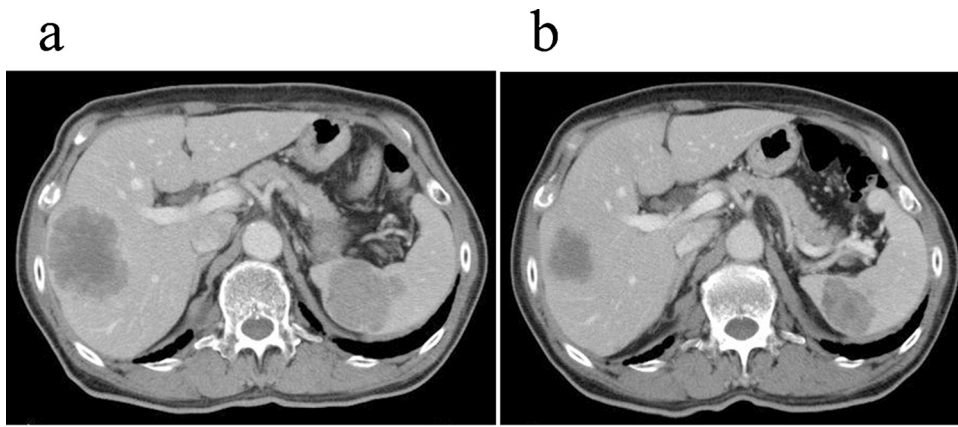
Abdominal computed tomography (CT) findings. (a) before rectal surgery (b) after chemotherapy. An abdominal CT scan performed after chemotherapy demonstrated significant reduction in the hepatic and splenic tumors.
